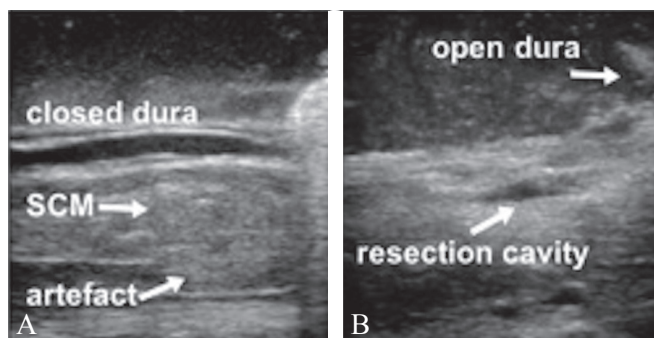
A 32-year-old woman with a SCM at the level of T 9 (case #1; operative group) intraoperative high frequency ultrasound (A) SCM before dura opening (B). The resection cavity with open dura. The accurate differentiation of medullary to possible residual pathological tissue is hindered due to perifocal edema. The patient presented with acute symptoms (3 days) and underwent a left unilateral laminectomy of T 9 and extirpation of the lesion.
